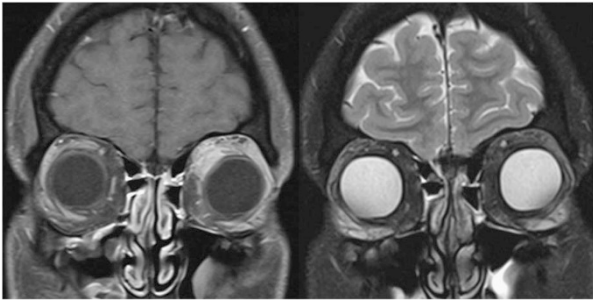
MRI scans of patient four before and after treatment. Left: pre-treatment coronal T1-weighted MRI with fat suppression and gadolinium contrast showing a mass in the superomedial left orbit. Right: coronal T2-weighted MRI 6 months post intraorbital triamcinolone injection showing complete radiological resolution.
